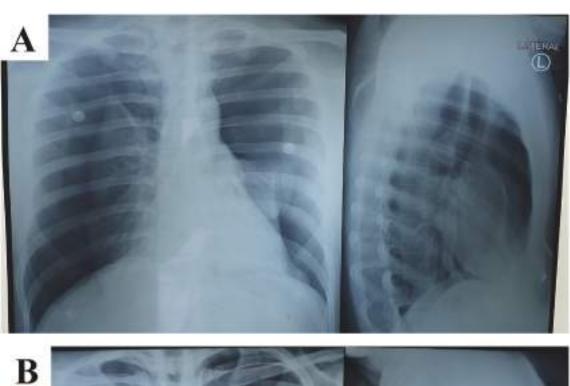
A. Chest X-ray of anterior-posterior and left lateral before chest tube insertion; B. Chest X-ray of anterior-posterior and left lateral after chest tube insertion.
